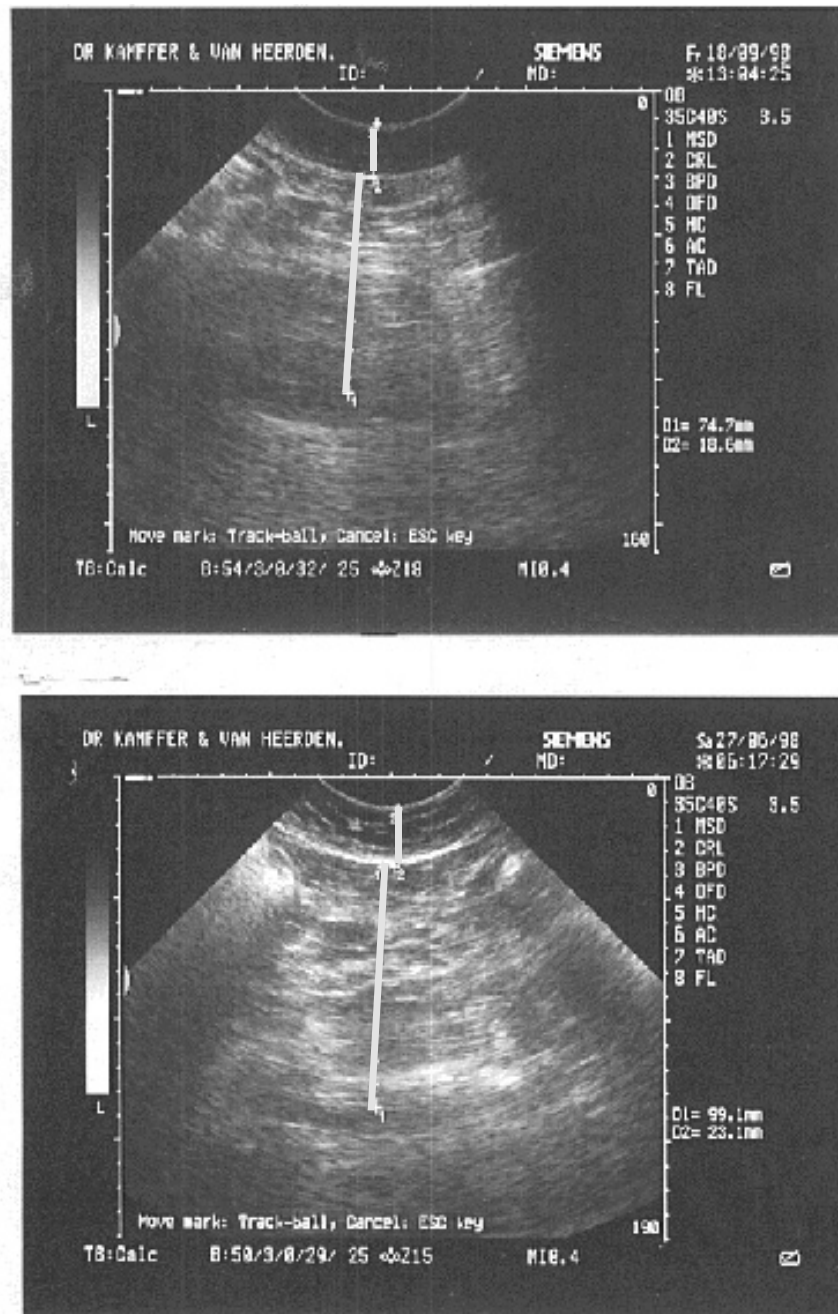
ULTRASOUND MEASUREMENT OF SUBCUTANEOUS ABDOMINAL AND VISCERAL FAT IN TWO BLACK DIABETIC SUBJECTS
